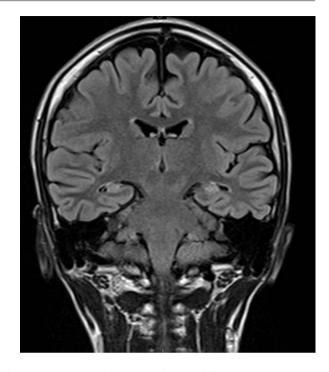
MRI scan showing bilateral hippocampal sclerosis
